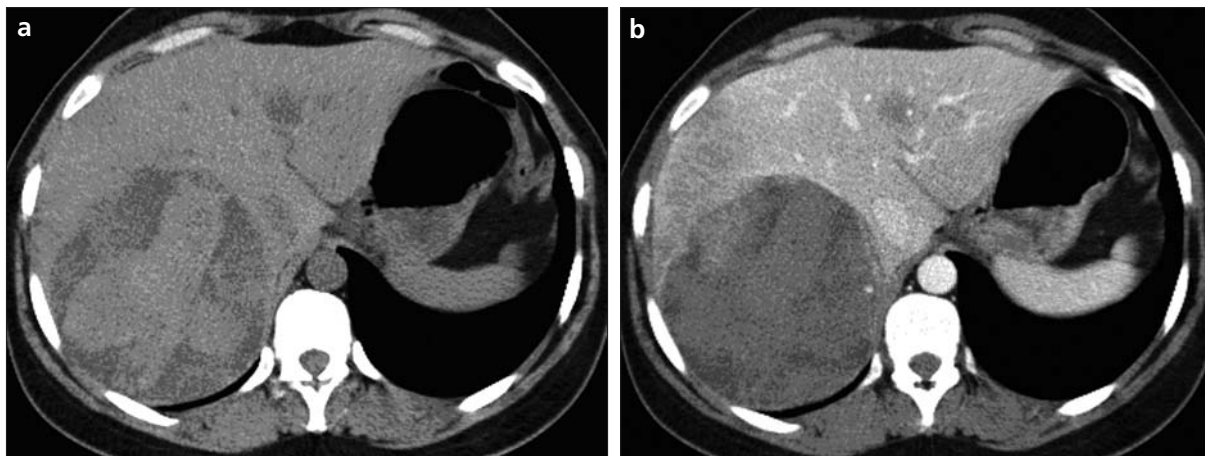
a–c. Precontrast transverse CT image (a) shows heterogenous mass in the posterior segment of the right lobe of the liver. In the postcontrast portal phase (b), there is minimal enhancement in the anterior part of the lesion which showed a washed-out appearance in late phase (c) imaging. There was another hypodense mass in left lobe of the liver.
